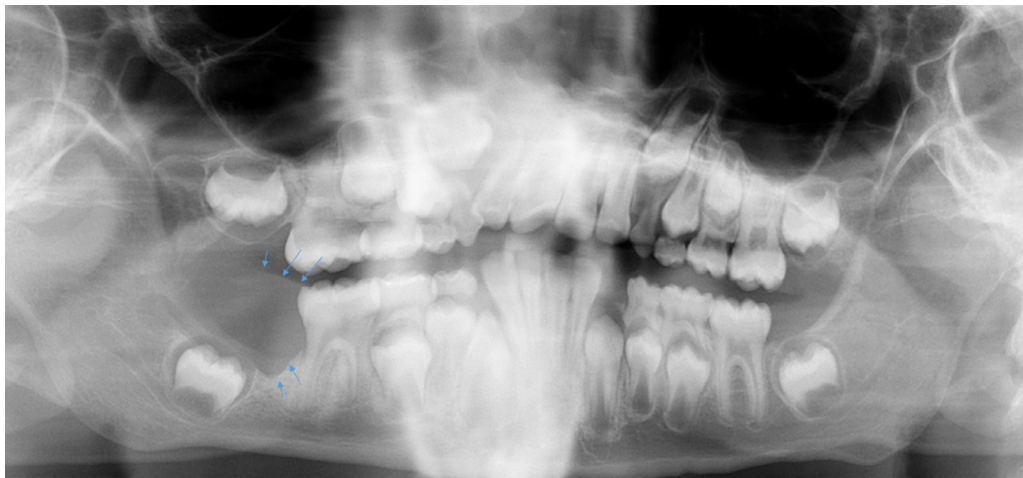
Panoramic radiograph is depicting superficial resorption (cupping) of the alveolar bone crest produced by a peripheral posterior to the first permanent molar.
